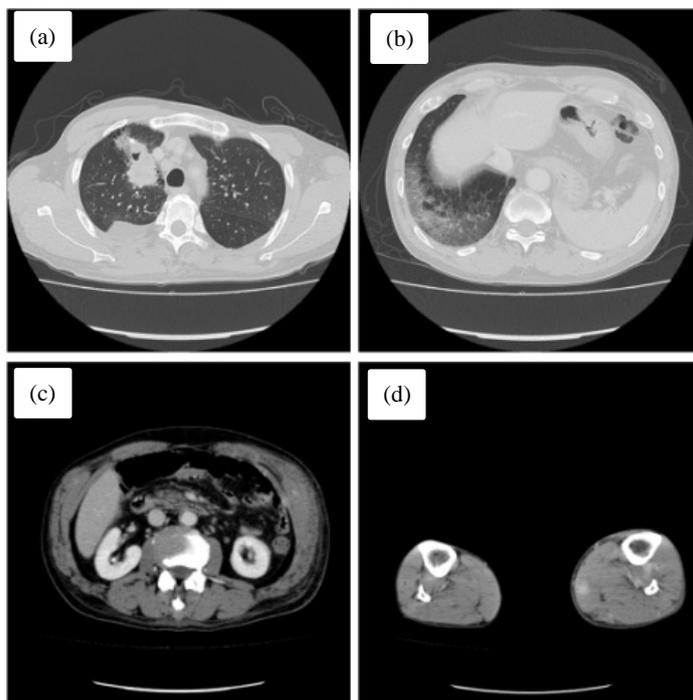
Contrast-enhanced computed tomography findings. (a) Lung mass on the right upper lobe; (b) ground-glass opacities on the right inferior lobe that may indicate alveolar hemorrhages; (c) intramuscular hemorrhage of the left abdominal oblique muscles; (d) intramuscular hemorrhage of the bilateral calves.
